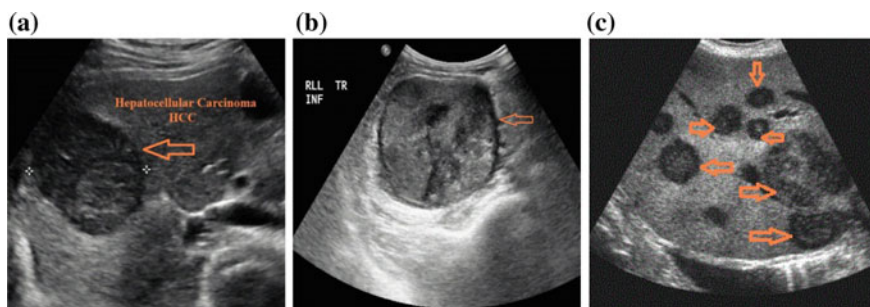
Ultrasound liver images with different appearance of Hepatocellular carcinoma, a small HCC, b large HCC, and c multiple masses
